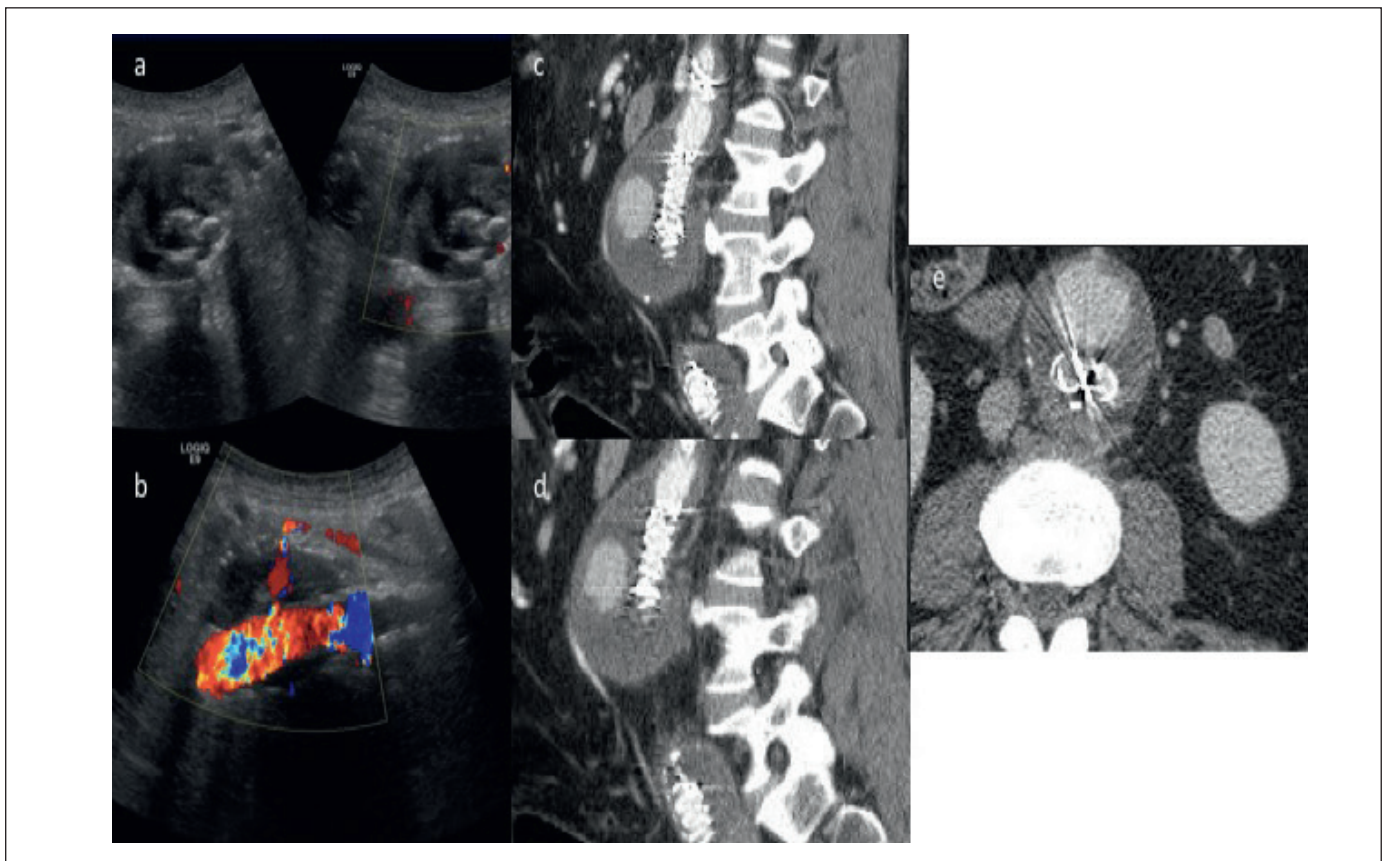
Type II IMA Endoleak. Axial (a) greyscale and sagittal (b) Doppler sonograms demonstrate extensive heterogeneity (concerning for endoleak) within the native aneurysmal sac anteriorly with Doppler flow at the native IMA origin. Sagittal (c,d) and axial (e) contrast CT demonstrate endoleak originating from the IMA.
